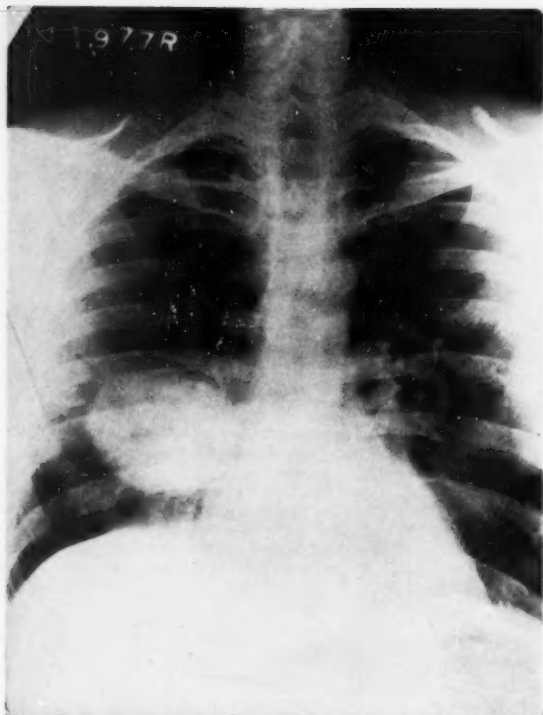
Chest x-ray of same patient (H. D.) on 49th hospital day showing residual pulmonary involvement.
